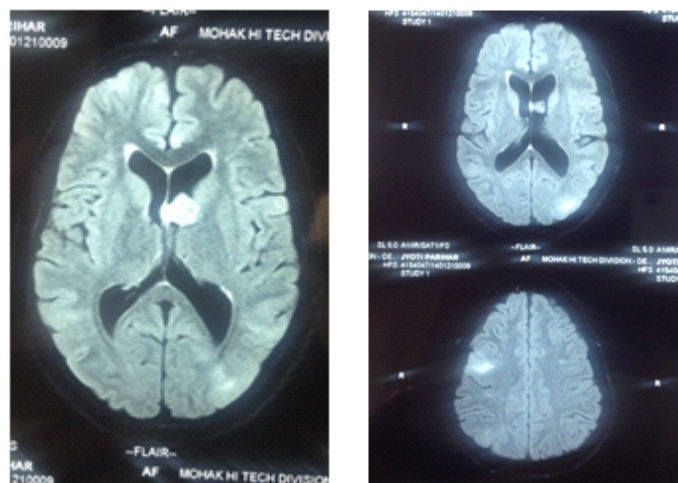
MRI Brain showing Subependymal Giant Cell Astrocytoma of left Frontal Horn with white matter radiation lines
